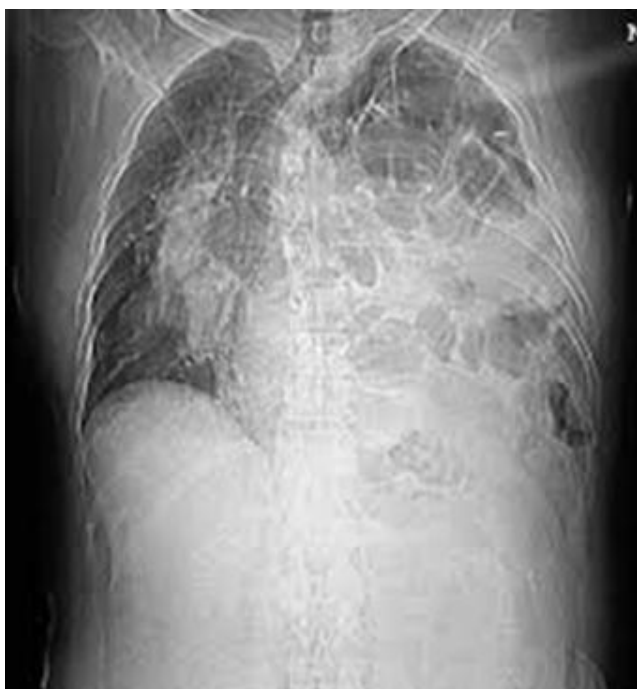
Chest radiography: complete opacity of the left thorax
